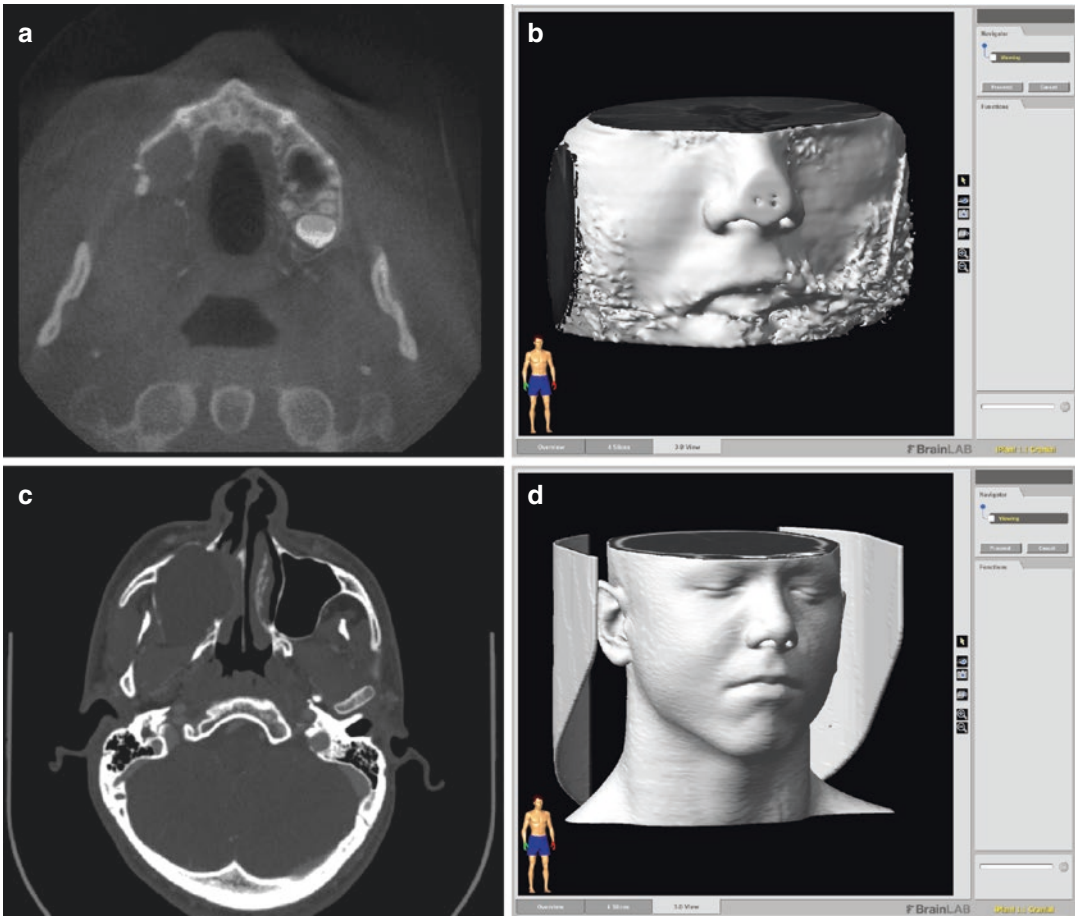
Image resolution and contrast are important for two reasons in image-guided surgery: On the one hand, they add to the diagnostic image quality and should ease the identification of structures that may be the target of an image-guided intervention or are to be avoided (Rouas et al. 2007). Furthermore, information is needed to create a geometric model of the site of surgery. With some deviations from the gold standard CT, this can be achieved with the image data from existing CBCT systems (Loubele et al. 2006). Furthermore, CBCT data can be used to assess bone quality for dental implant planning (Lee et al. 2007).
